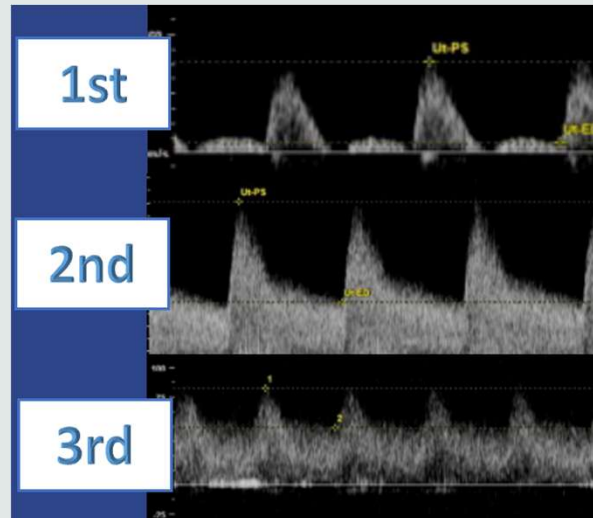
Spectral Doppler waveform of the gravid uterine artery in the first, second and third trimesters.<sup>8</sup>
